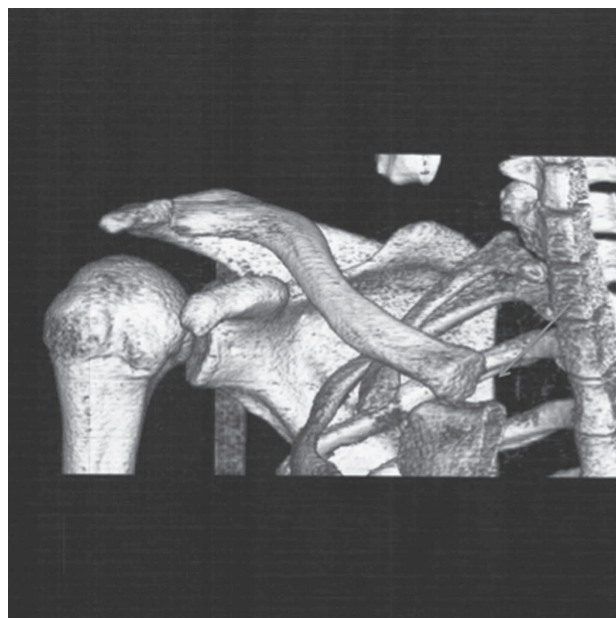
Computed tomographic 3-dimensional reconstruction of the right SC joint.
